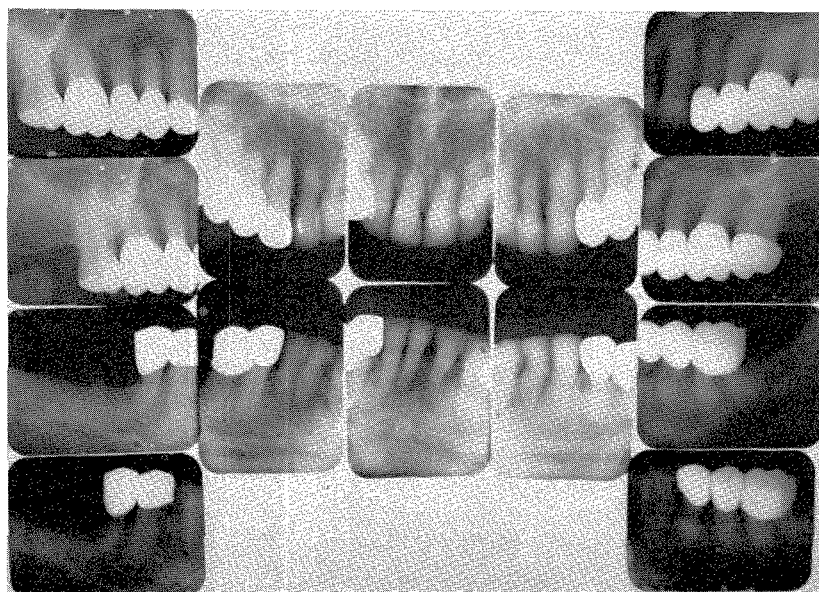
Roentgenograms of the completed work. These were taken in February, 1954.
